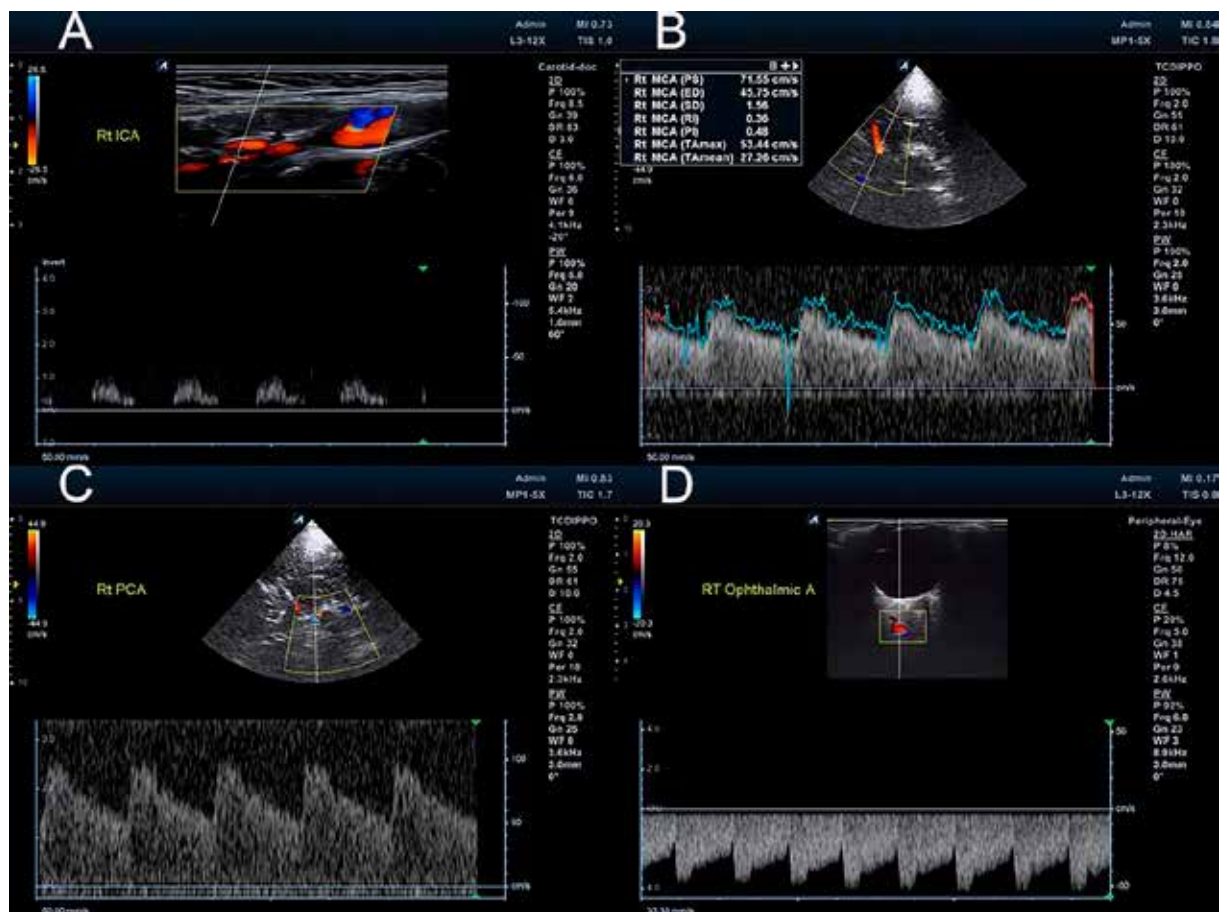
Color-coded doppler ultrasound of the carotid one week after the initial diagnosis. A. Pathological flow in the right internal carotid artery suggestive of recanalisation of priorly occluded vessel. B. Slightly educed maximum systolic speed and PI of the right MCA suggestive of a good collateral supply of the MCA and distal vasodilation. C. Increased maximum systolic speed of the right PCA suggestive of an hyperdynamic flow of the supplying the leptomeningeal arteries as a collateral arterial network. D. Retrograde flow of the right ophthalmic artery exhibiting a similar flow profile to right MCA, suggestive of its role as a collateral artery supplying the right MCA.
